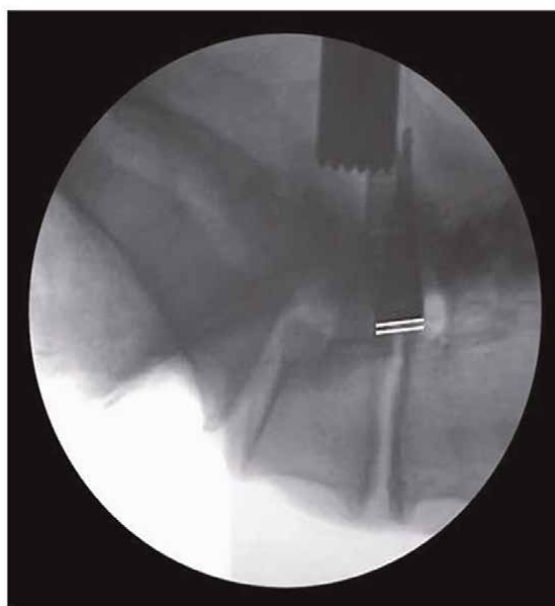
PreReciprocation Lateral Fluoroscopy: The microblade shaver is slowly inserted into the neuroforamina and a lateral radiograph is obtained. The baseline anteroposterior foraminial depth is delineated by the white reference lines depicting the anterior aspect of the microblade shaver in relation to the posterior margin of the vertebral body. Note the decreased neuroforaminal volume present.
